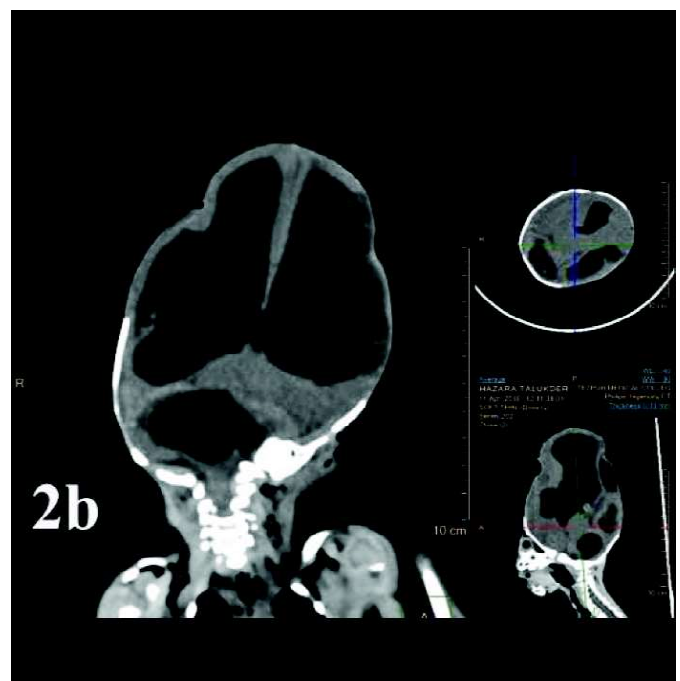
CT scan showing development of the brain with gross hydrocephalus
